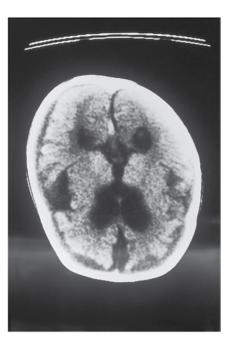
The sister of the patient in Figure 46.7. She was diagnosed late. The CT scan at 10 months shows considerable evidence of cerebral atrophy. She was severely impaired neurologically and died at 19 months.
